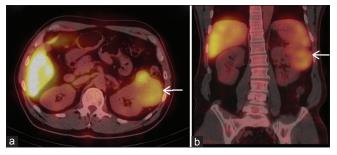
Fused axial single-photon emission computerized tomography (SPECT)- computerized tomography (CT) (a) and Fused coronal SPECT-CT (b) images 4 days after injection of In-111 ProstaScint® shows abnormal uptake in the exophytic mass arising from superior pole of left kidney (arrows)
